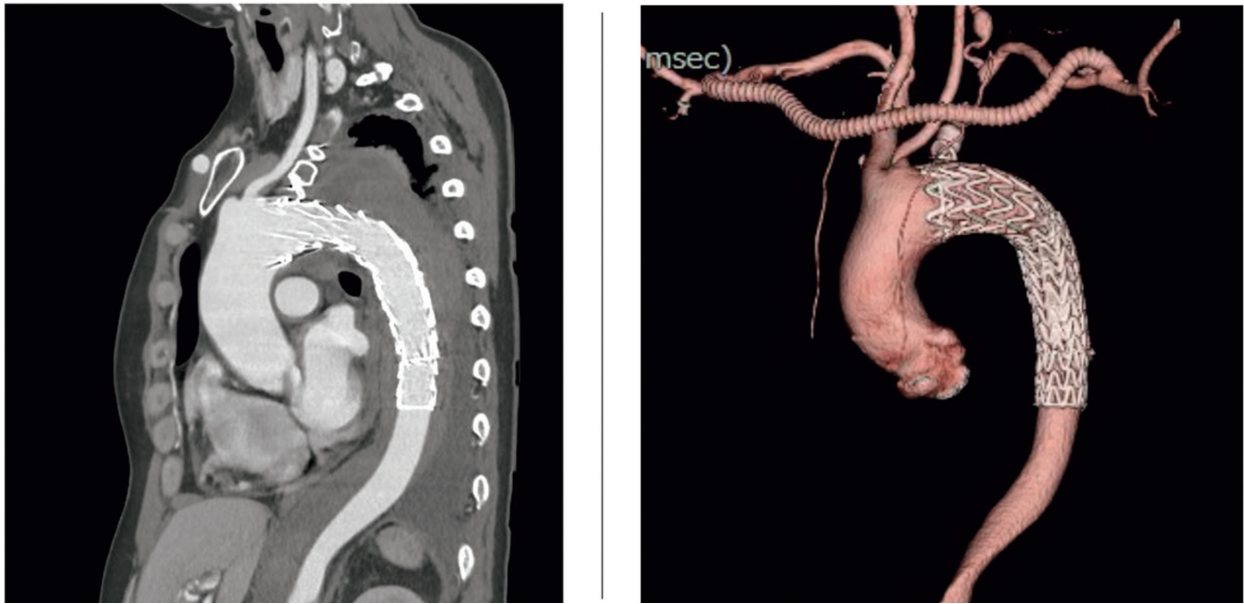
Postoperative contrast-enhanced computed tomography showed thrombosis of the false lumen two weeks after thoracic endovascular aortic repair.
